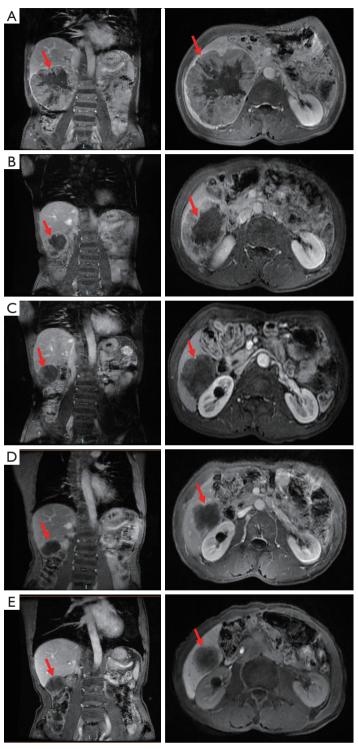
MRI scan image showing the progress of HCC. (A) Baseline condition of the tumor before treatment. Primary huge lesion of HCC (red arrows). (B) The tumor condition after two cycles of treatment. A notable reduction in the size of the HCC (red arrows). (C) The tumor condition after eight cycles of treatment. The tumor lesion has continued to decrease in size (red arrows) and has achieved PR. (D) Post-operative situation of MWA. The tumor focus was reduced in size compared to its previous dimensions (red arrows). (E) The last follow-up imaging assessment. The size of the tumor lesion in the right lobe of the liver has remained stable (red arrows). MRI, magnetic resonance imaging; HCC, hepatocellular carcinoma; PR, partial response; MWA, microwave ablation.
